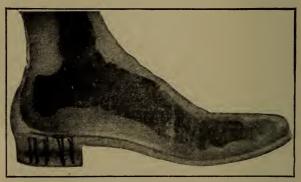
An X-ray view of the human foot in a hygienic low-heeled shoe. (Note that none of the bones are cramped.)
